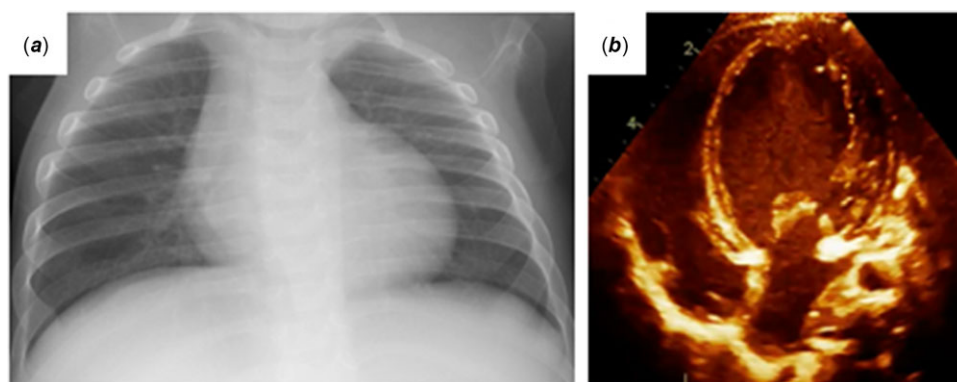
(a) Chest radiography on discharge. (b) Echocardiography on discharge.
